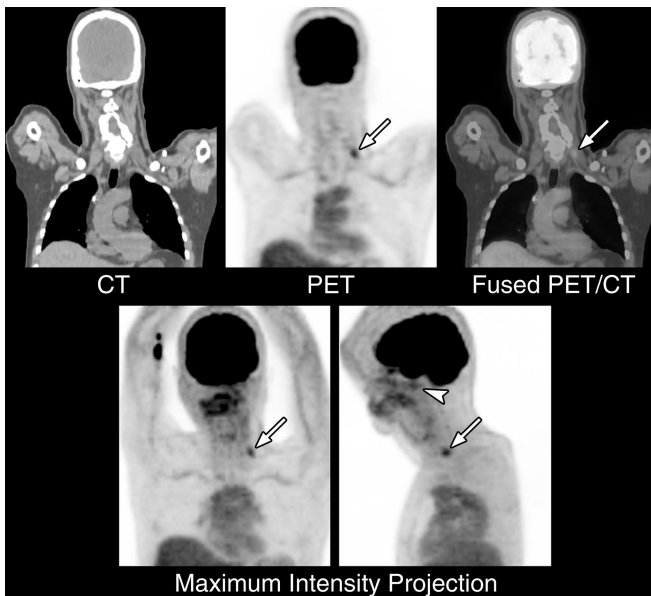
The FDG PET/CT demonstrated mildly increased radioactivity in the nasopharyngeal region (arrowhead) that was probably due to the inflammation. However, there was an unexpected focus with intense radioactivity (SUVmax: 3.6) in the left lower neck region (arrows). Initially, the finding was suspected as lymph node metastasis that would be regarded as progression of malignancy. However after carefully examining the anatomic reference on CT component of FDG PET/CT, the lesion seemed unusually deep and possibly within the left scalene muscle.
